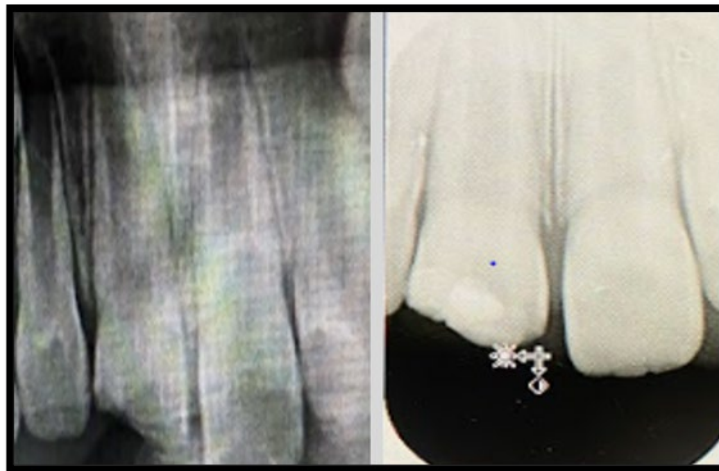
Pre- and post-partial pulpotomy periapical radiographs.
